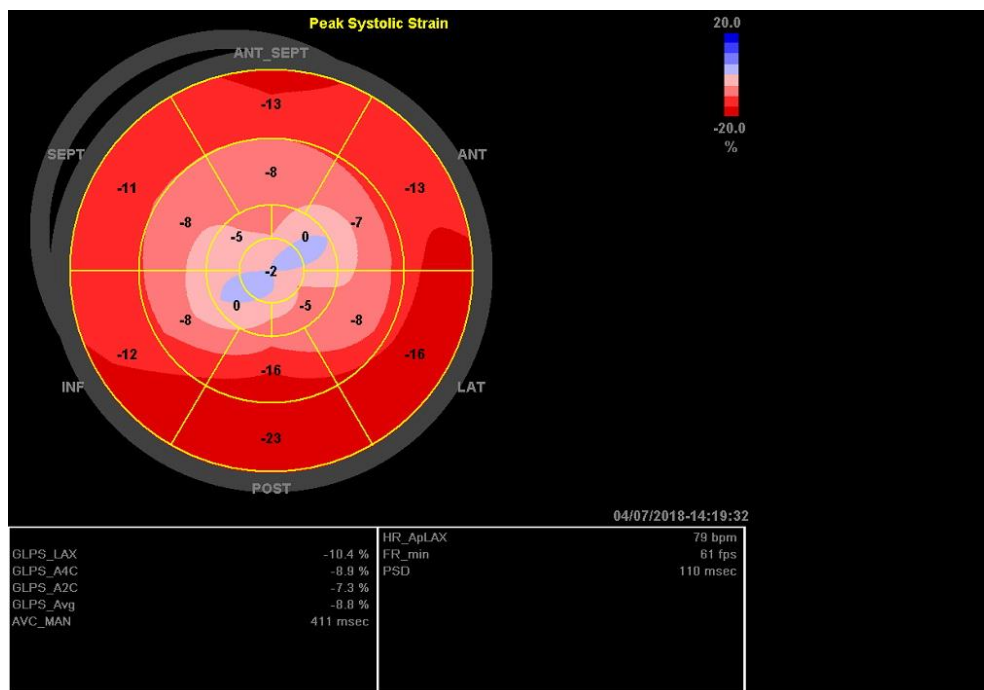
A typical transthoracic echocardiography from a patient with Takotsubo cardiomyopathy (TTC).
